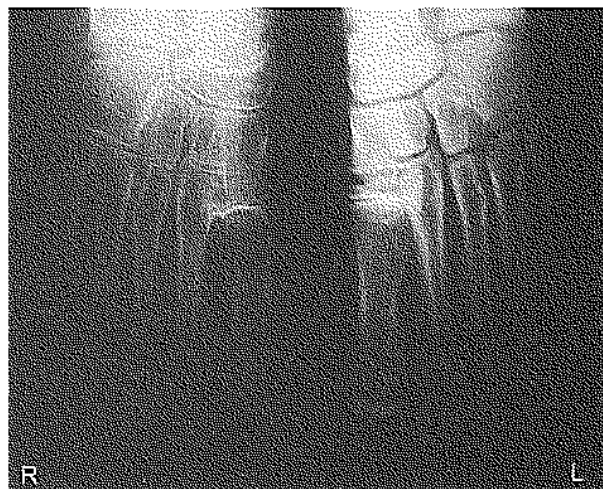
Fine-detail x-rays of the feet of a patient with RSDS, showing the normal left foot (L) and the demineralization in the affected right foot (R).
